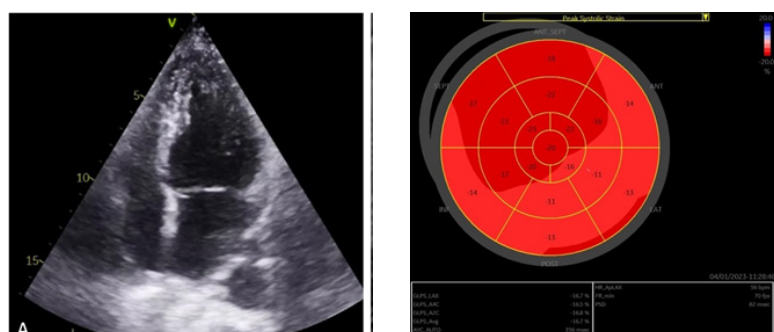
Echocardiogram showing absent apical ballooning, but present inferior akinesia (2A); Strain analysis confirmed reduced deformation in the basal inferior and inferolateral segments, with preserved apical strain (2B).*
